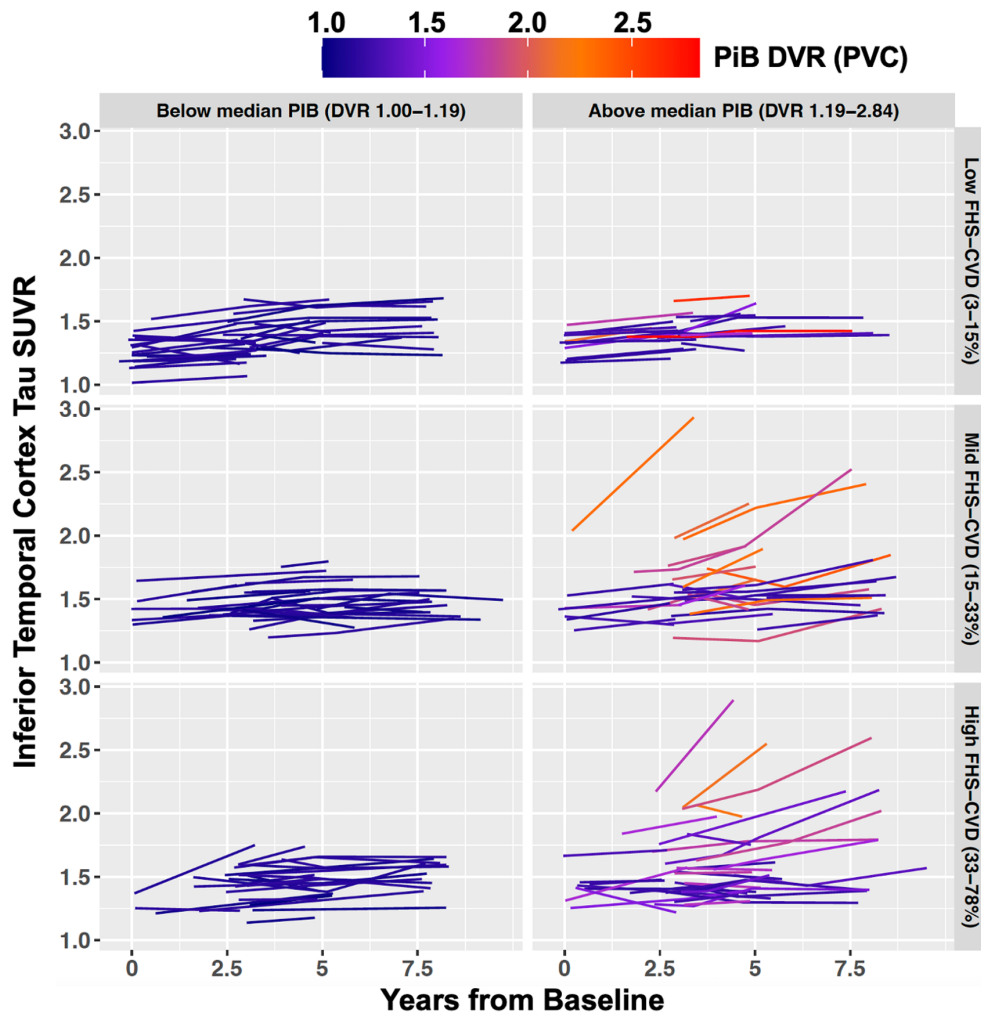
Accumulation of tau pathology as a function of baseline A β burden and level of systemic vascular risk. Individual ITC tau burden trajectories from all participants are shown. To allow clear visualization of individual tau trajectories, participants were divided according to baseline A β burden (by median split) and the FHS-CVD (by tertiles) using cutoffs shown in the facet labels for the columns and rows, respectively. The trajectories are color coded by baseline A β burden according to the color bar, with each line representing one participant. The time of baseline PiB PET was used as the study baseline (time = 0). Timing of the first tau PET scan varied across participants (2.1 ± 1.5 years), as tau PET was introduced mid-study in HABS. A β = β -amyloid; FHS-CVD = Framingham Heart Study cardiovascular disease risk score; DVR = distribution volume ratio; HABS = Harvard Aging Brain Study; ITC = inferior temporal cortex; PVC = partial volume correction; PET = positron emission tomography; PiB = Pittsburgh Compound-B; SUVR = standardized uptake value ratio.
